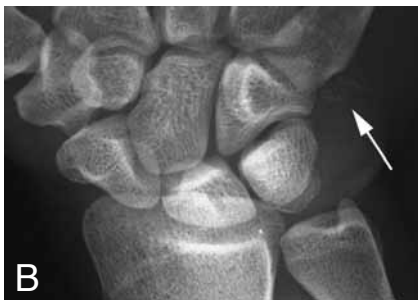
Calcifications in loiasis. Plain radiograph of right hand.
